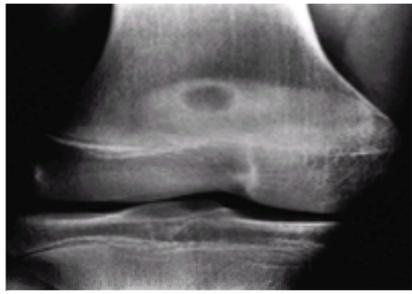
Dorsal defect of the patella. The typical lesion is a round, radiolucent area in the superolateral pole of the patella. The margins of the lesion are well circumscribed. This is best seen on the anteroposterior radiograph. Typically, the lateral radiograph is normal.
